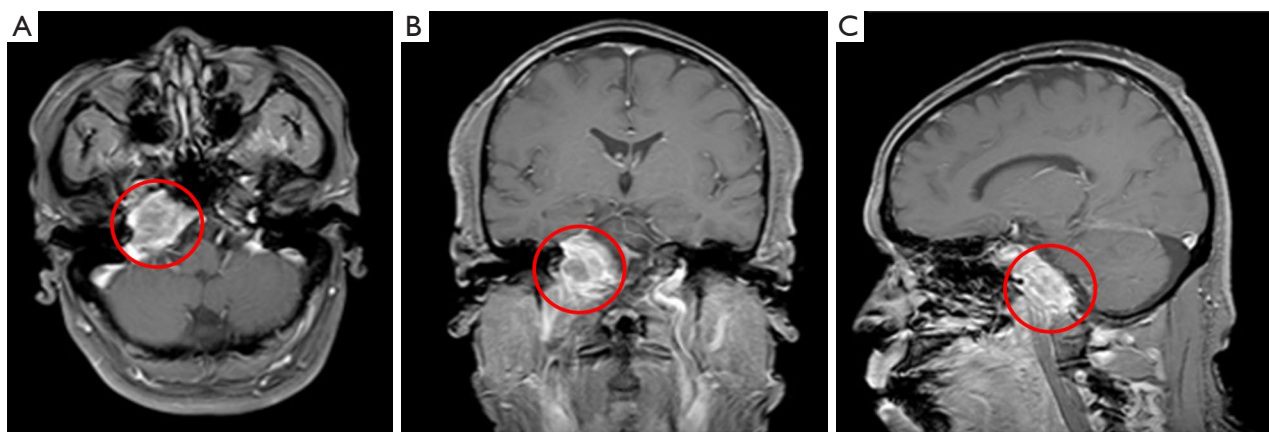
The patient's enhanced cranial MRI upon admission (February 14, 2023) shows a slightly indistinct border mass in the right temporal bone measuring approximately 3.5 cm × 2.1 cm. (A) Axial, (B) coronal, and (C) sagittal views of enhancement after contrast administration is significantly uneven and involves the left cavernous sinus, sphenoid sinus, and slope. The location of the tumor operative zone is circled in red in the figure. MRI, magnetic resonance image.
